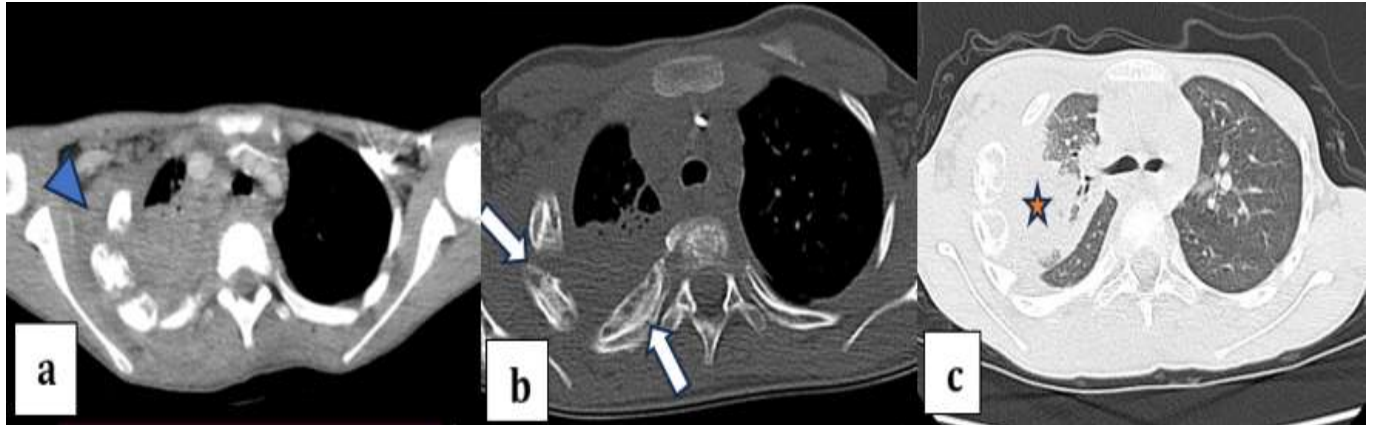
Thoracoabdominopelvic CT scan in the mediastinal window (a), bone window (b), and lung window (c) showing: A tumor-like tissue mass in the right lateral chest wall (arrowhead) with bone involvement (arrow) and right upper lobar condensation (star).
